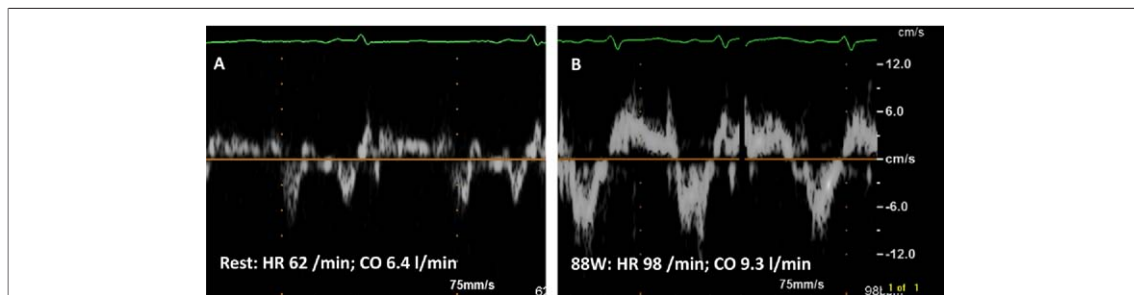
Pulsed Wave Tissue Doppler Recordings From Septal Mitral Annulus
